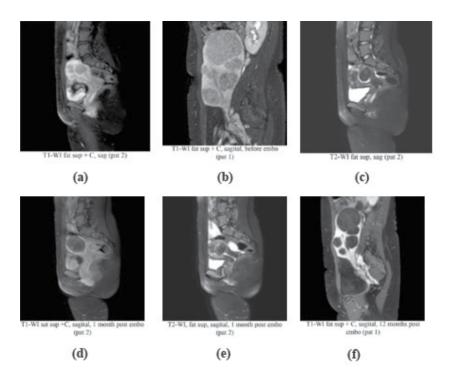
MRI imaging of fibroid course pre- and post embolization.
